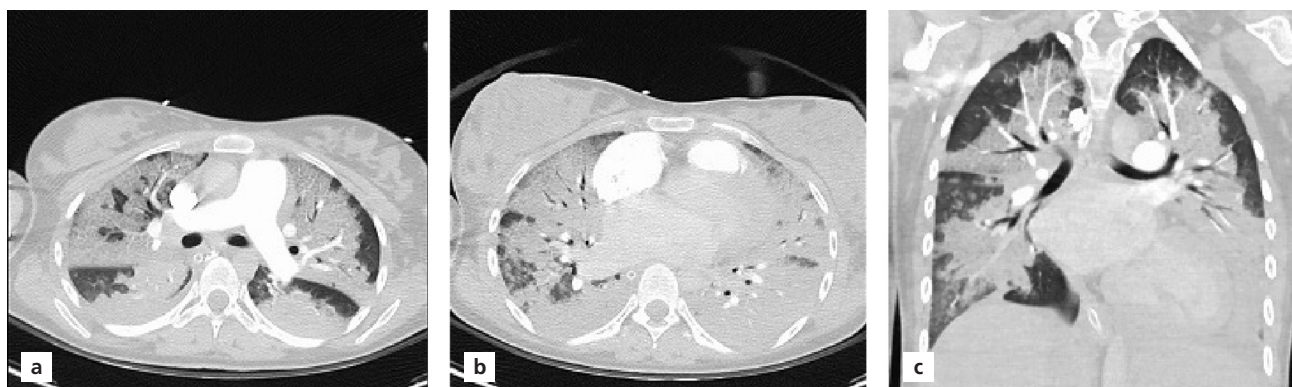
(a–c) Pulmonary CT scan before the treatment.
